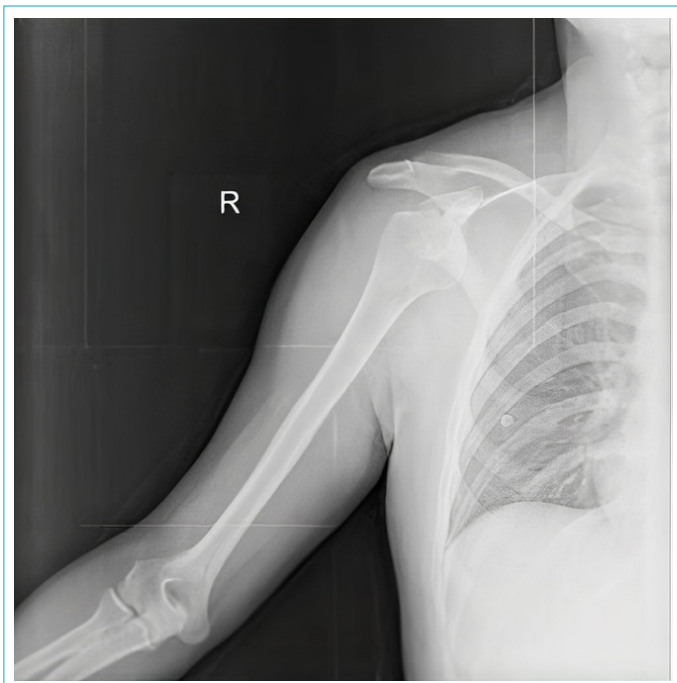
Male patient, 39 years old; AP X-rays of the right shoulder show bilateral anterior shoulder dislocation.
